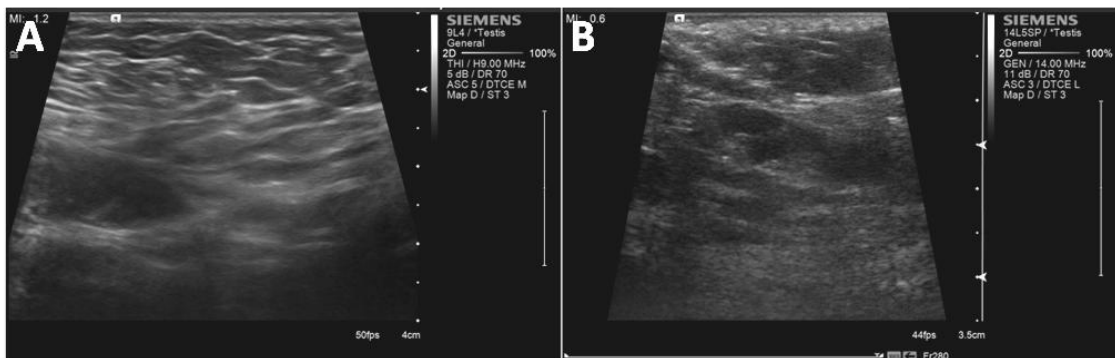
Adhesion deformation via transverse ultrasound imaging of the scrotum. (A) Before therapy: thickened scrotal wall with complex echogenicity. (B) After treatment: improvement in the scrotal wall and echogenicity.⁴
